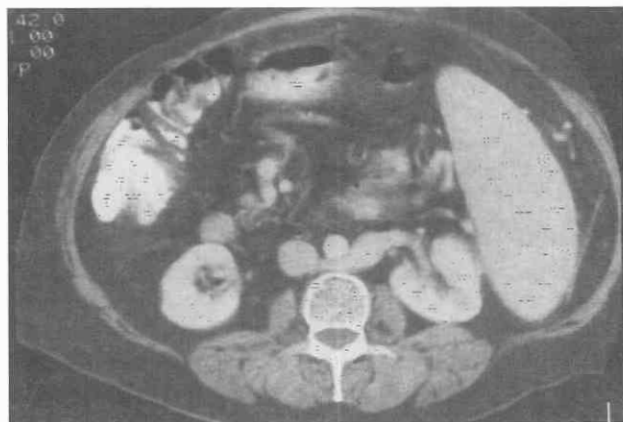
Retroaortic left renal vein in a patient with splenomegaly, as seen on a dynamically enhanced CT scan.
